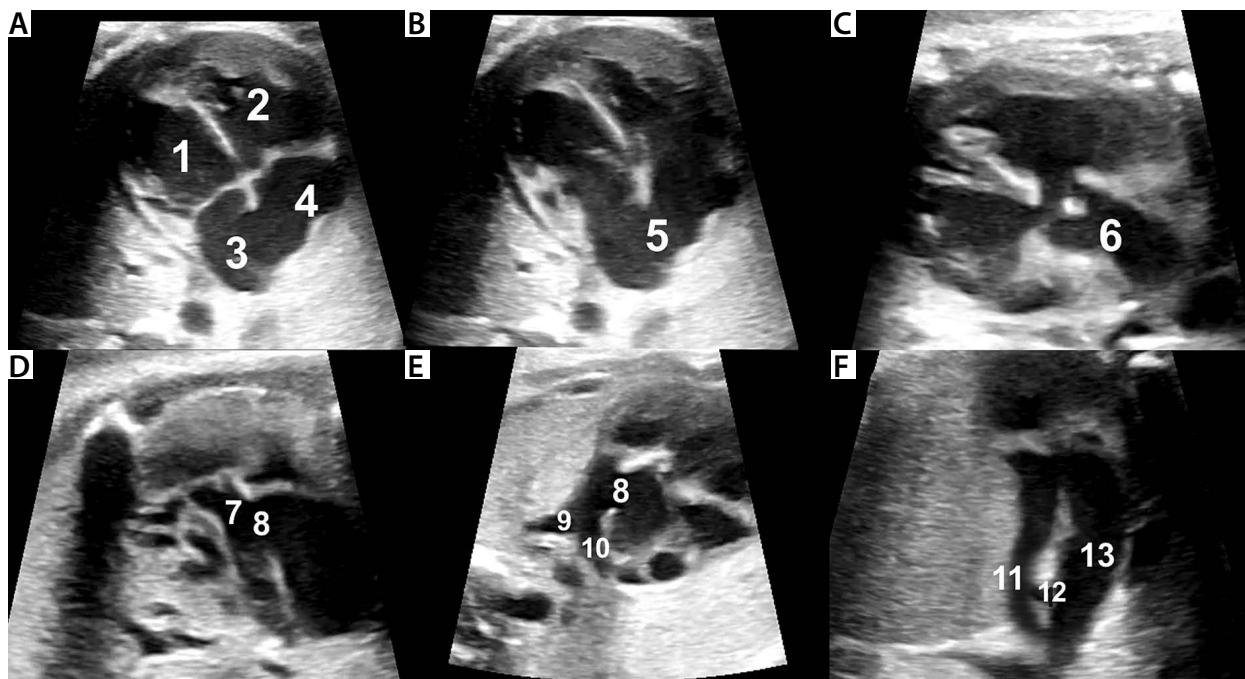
Fetal echocardiography at 31 weeks of gestation: A – a four-chamber view in systole; B – a four-chamber view in diastole; C – the left ventricular outflow tract; D – the right ventricular outflow tract; E – a short-axis oblique view showing aortopulmonary window; F – a three-vessel and tracheal view – the right-sided aortic arch and the left-sided arterial duct are visualised
